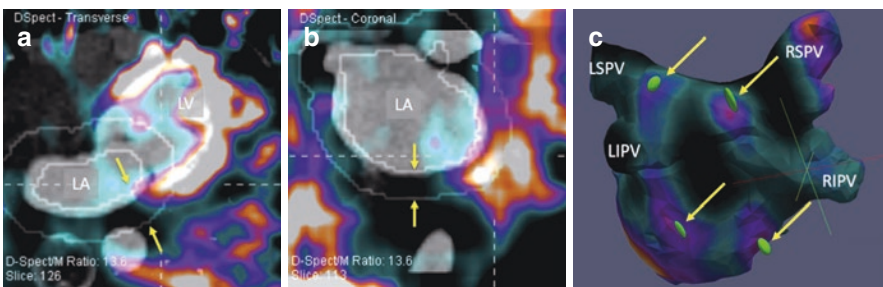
(a, b) Co-registered SPECT ^{123}I -mIBG and cardiac CT images in transverse (a) and coronal (b) planes. The LA region of search is defined (solid lines, arrows) by the CT-derived LA compartment. (c) Color-coded 3D maps of ^{123}I -mIBG uptake and distribution on CT-derived LA compartments, as well as 3D ellipsoidal DUA representations (ellipsoids, arrows). *LSPV* left superior pulmonary vein, *LIPV* left inferior pulmonary vein, *RSPV* right superior pulmonary vein, *RIPV* right inferior pulmonary vein, *DUA* discrete uptake area, *LA* left atrium, *LV* left ventricle. (Modified with permission, from Stirrup, J., Gregg, S., Baavour, R. et al. *J. Nucl. Cardiol.* 2019 [136])
